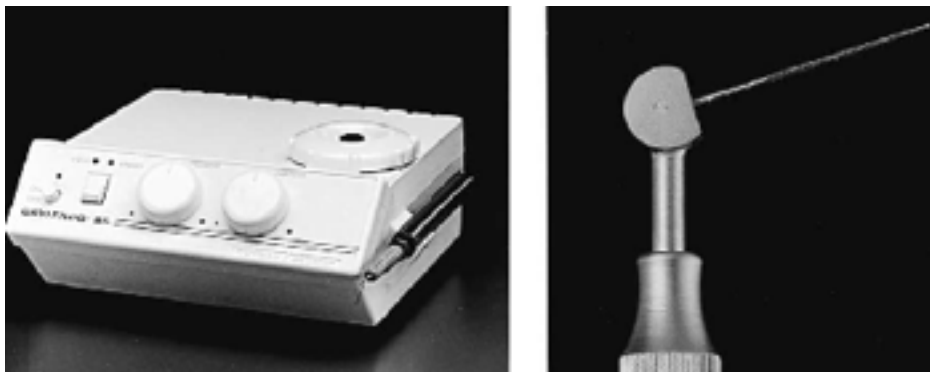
An ultra sonic unit (left) and the ultrasonic tip (right)
